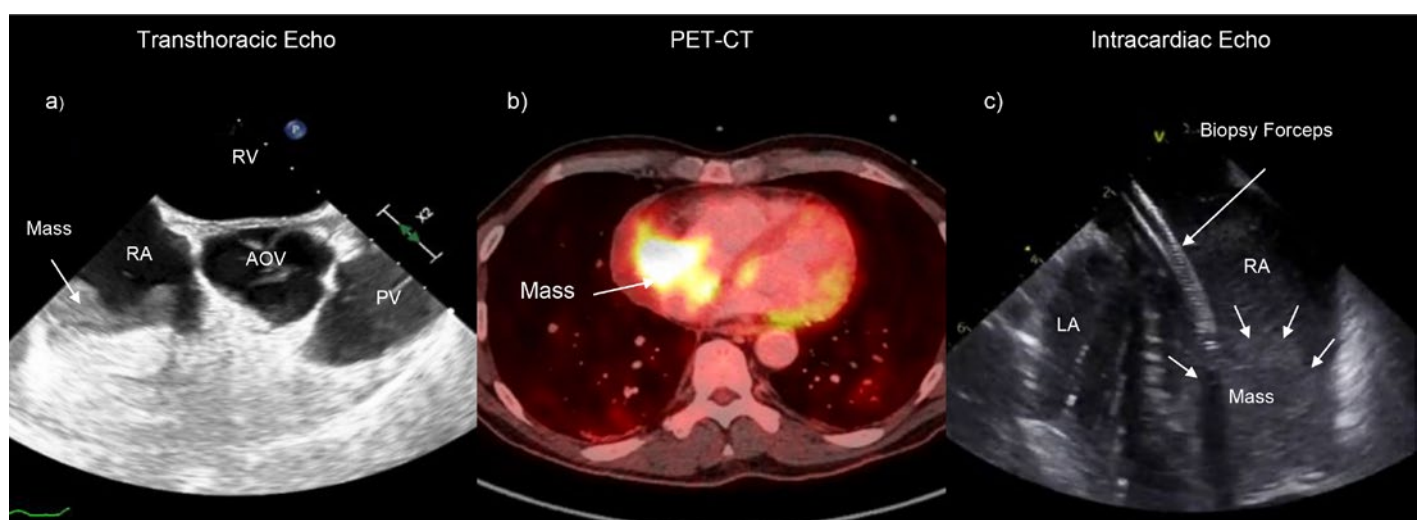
Panel encompassing several imaging modalities of the cardiac tumour. a) Transthoracic echocardiography (parasternal short axis view) demonstrating an unclear hyperechogenic mass in the posterior right atrial wall. b) Positron emission tomography–computed tomography (PET-CT) view – a contrast-capturing structure in the posterior free wall of the right atria can be observed. c) Intracardiac echography showing the biopsy forceps and the right atrial tumour. AOV = Aortic Valve, LA = left atrium, PV = Pulmonary valve, RA = right atrium, RV = right ventricle.
